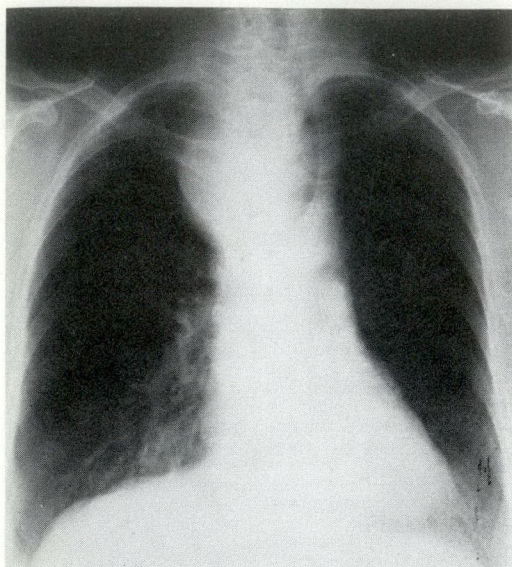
Radiograph of the chest showing deviation of trachea by a soft tissue mass.
